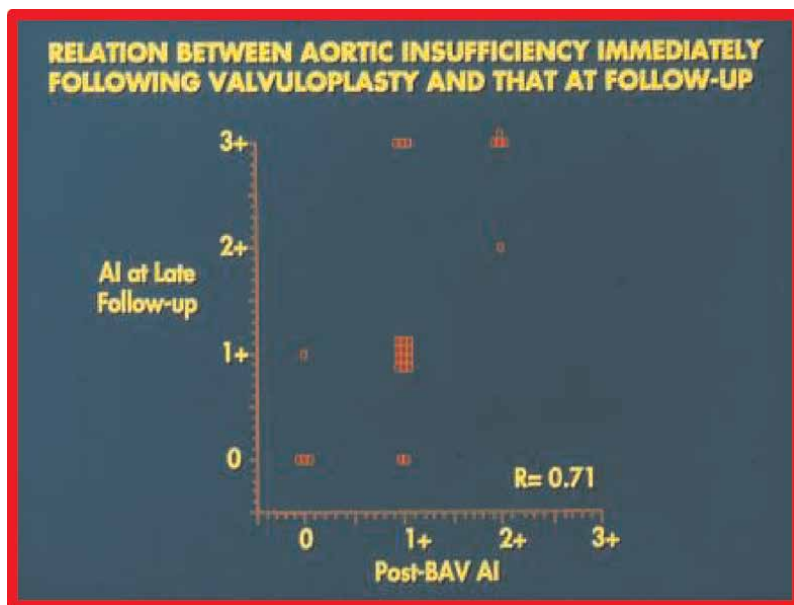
Relationship of immediate post-valvuloplasty Doppler-estimated aortic insufficiency (AI) with AI at late follow-up after balloon aortic valvuloplasty (BAV). Note good correlation ($R = 0.71$) between the two. (Modified from reference [7]).
